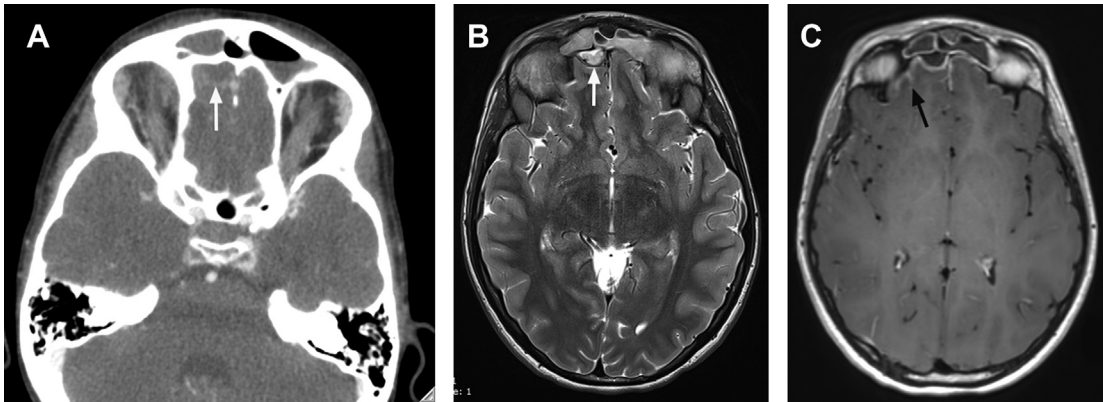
A 15-year-old boy with 4 days of headache, fever, and eye swelling due to acute, complicated sinusitis. Axial CT with contrast (A) and axial T2-weighted MR imaging (B) demonstrate frontal sinus opacification with air-fluid levels and a small right frontal epidural abscess (arrows). Postgadolinium 3D T1-weighted spin-echo sequence (C) shows leptomenigeal enhancement adjacent to the abscess (arrow), concerning for meningitis.
